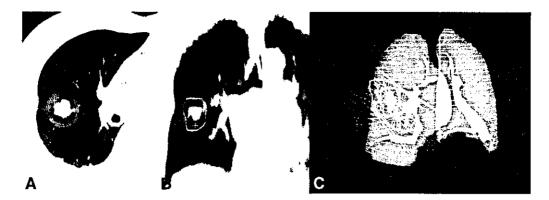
An example of three-dimensional treatment planning. (A) Isodose curves on axial CT through the center of the PTV. (B) Isodose curves on a coronal reconstructed image through the center of the PTV. (C) Three-dimensional image showing all radiotherapy arcs and isodose curves.
